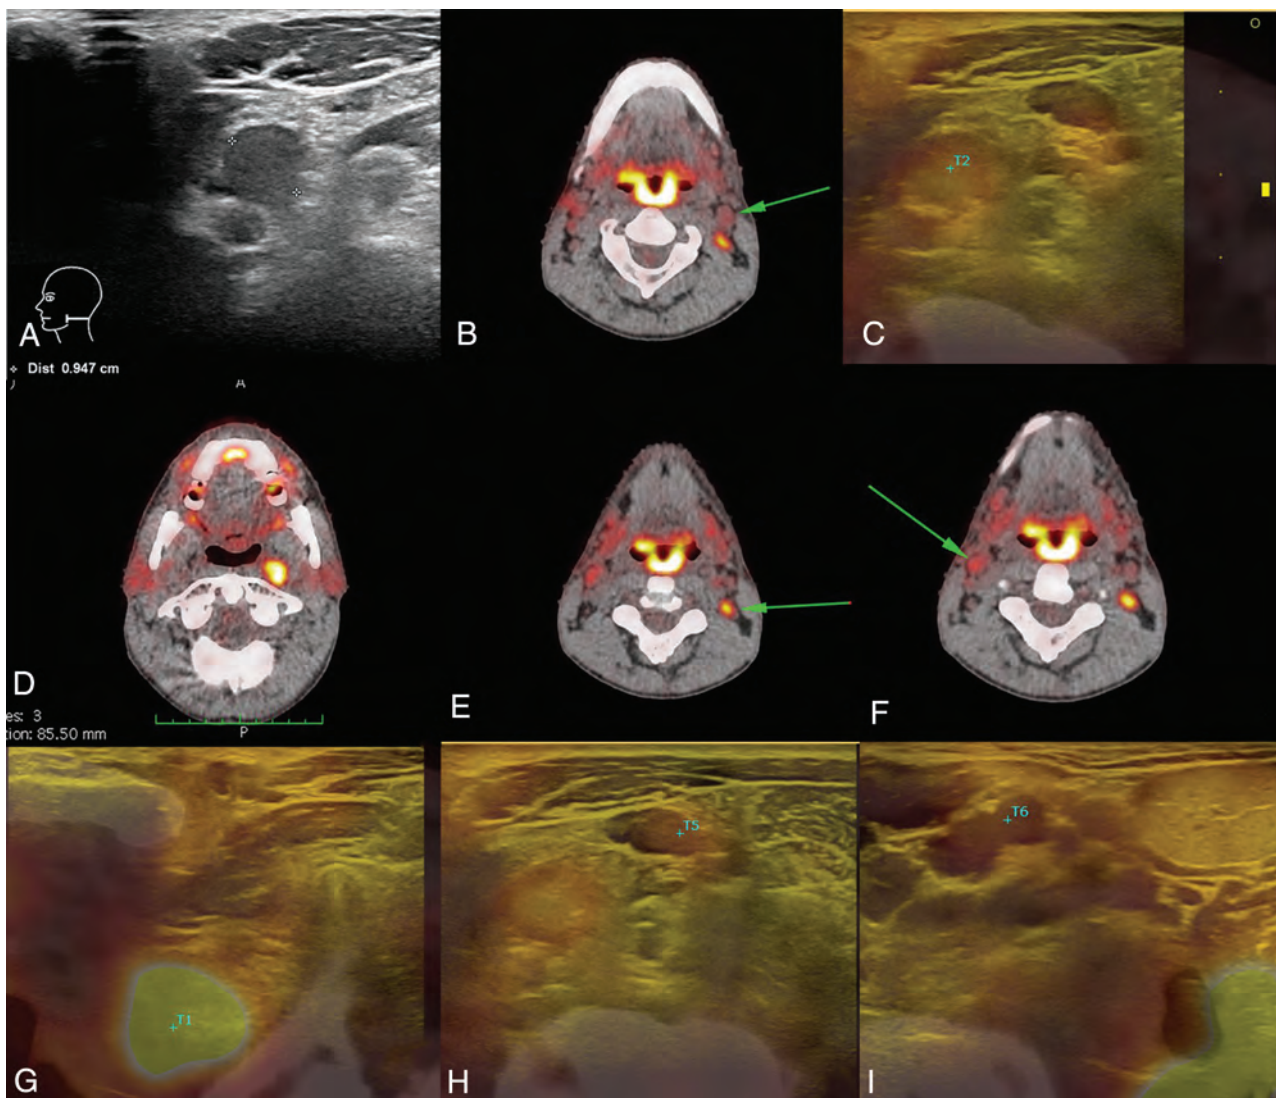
Change of N stage after additional fused-USgFNAC. The patient presented with cT3N0 oropharyngeal squamous cell carcinoma. A, Results of routine USgFNAC N1. B and C, PET/CT of the same node, controlled by image fusion. D–F, Additional nodes on PET/CT; all nodes have been fused, and fused-USgFNAC was performed. G, The deep parapharyngeal node was missed at routine ultrasound and only recognized after fusion. H, A PET-positive node with a normal appearance on routine ultrasound. I, Fused-USgFNAC-proved benign PET-positive contralateral node. Cytologically proved pN stage after fused-USgFNAC was pN2b, while it was N1 with USgFNAC and N2c on PET/CT. The green arrows point to the PET-positive nodes.
